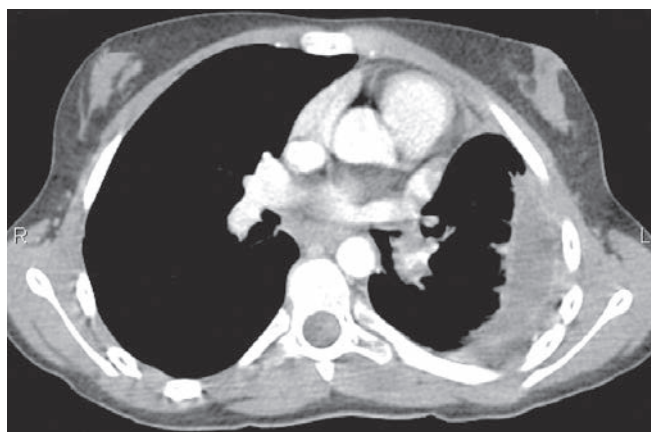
Computed tomography (CT) scan showing left-sided empyema
